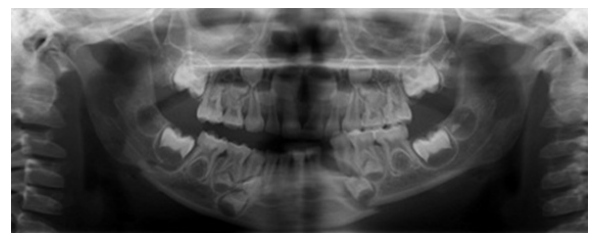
(b): CASE-2 pre operative radiographic findings
